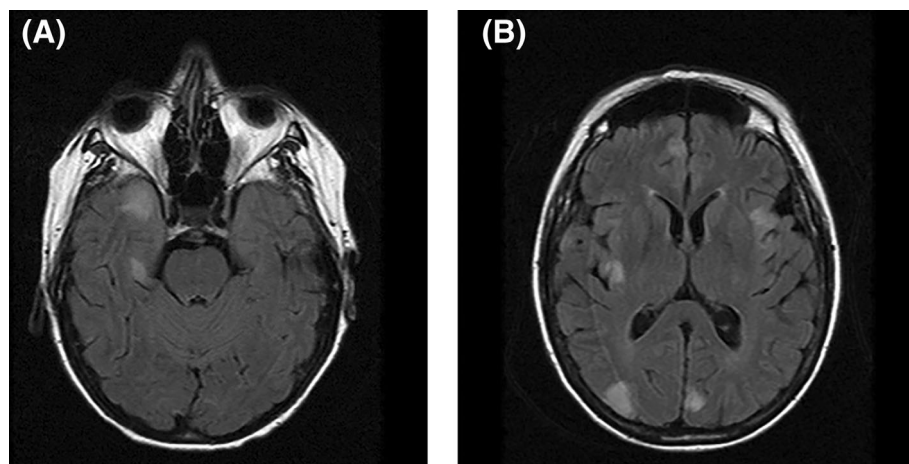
(A and B) Fluid-attenuated inversion recovery MRI in a woman with 10-day history of slurred speech, focal motor seizures in right face and tongue, malignant thymoma and GABA_aR antibody in serum and CSF.
